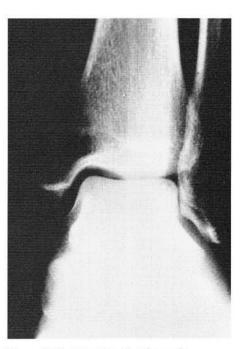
Preoperative AP radiograph.
